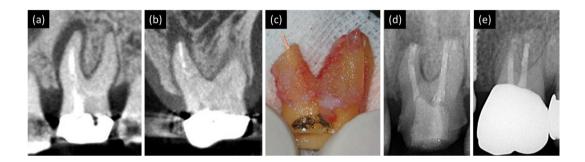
Successful case of a tooth #26 with root fracture during extraction; (a)~(b) Preoperative CBCT view, (c) Palatal root fracture during extraction, (d) Immediately after surgery, and (e) 2.5-year follow-up (complete healing)
